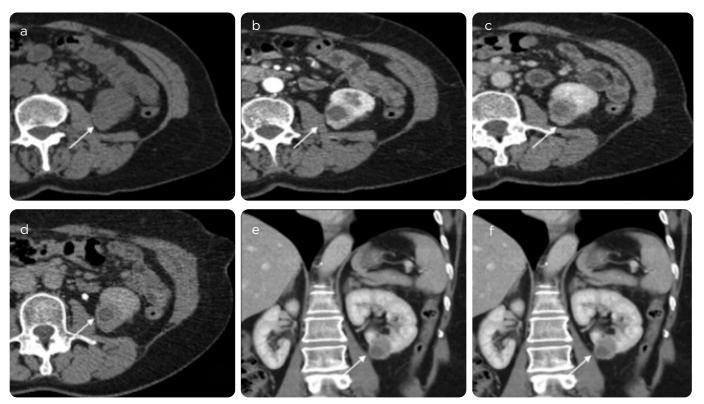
Solid cystic oncocytoma. CT scan, a) phase without contrast medium, corticomedullary (b axial, e coronal and f sagittal), c) axial nephrographic and d) axial excretory. Solid-cystic formation in the lower pole of the left kidney. Central region of low density that does not enhance in the phases with contrast medium and the rest of the tumor enhances especially in the corticomedullary phase (b), although to a lesser extent in relation to the adjacent parenchyma. The unenhanced area cannot be differentiated from necrosis which could be found in renal carcinoma with necrosis or cystic varieties.
